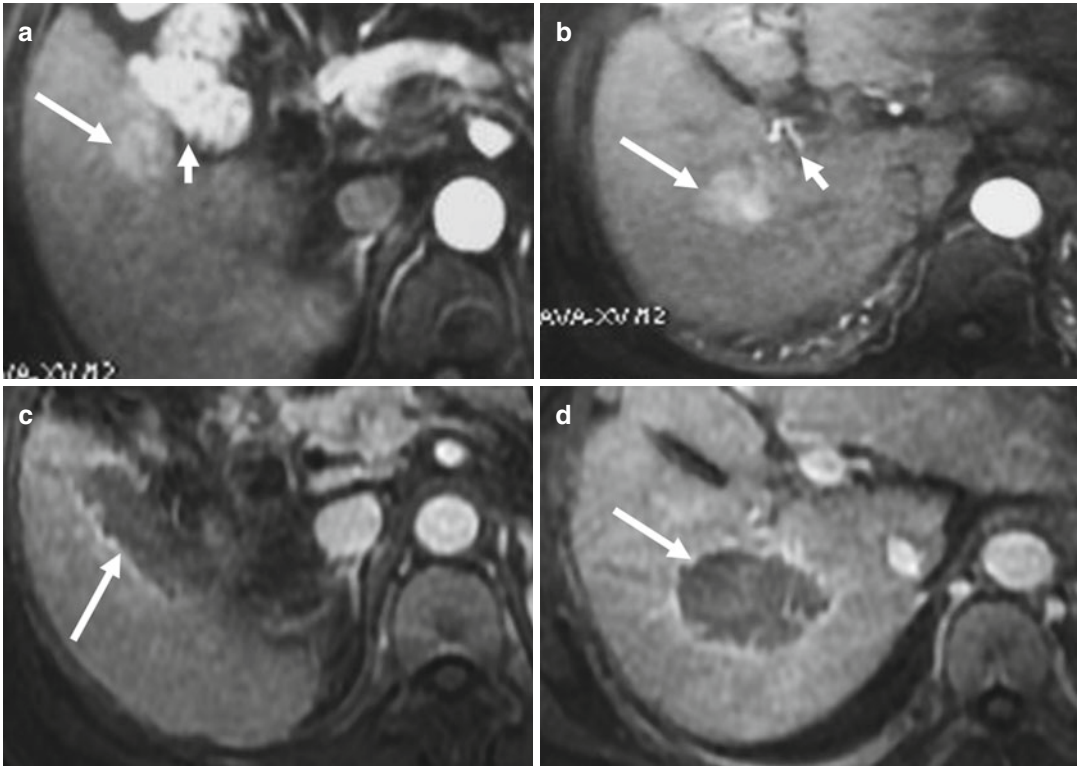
Transverse images in a 64-year-old woman with two hepatocellular carcinoma (HCC) lesions treated by microwave ablation (MWA). (a) Contrast-enhanced magnetic resonance imaging (MRI) before ablation shows a 2.7×2.5 cm hyperintense nodule (*long arrow*) adjacent to intestinal tract (*short arrow*) at arterial phase. (b) Contrast-enhanced MRI before ablation shows a 3.3×2.9 cm
